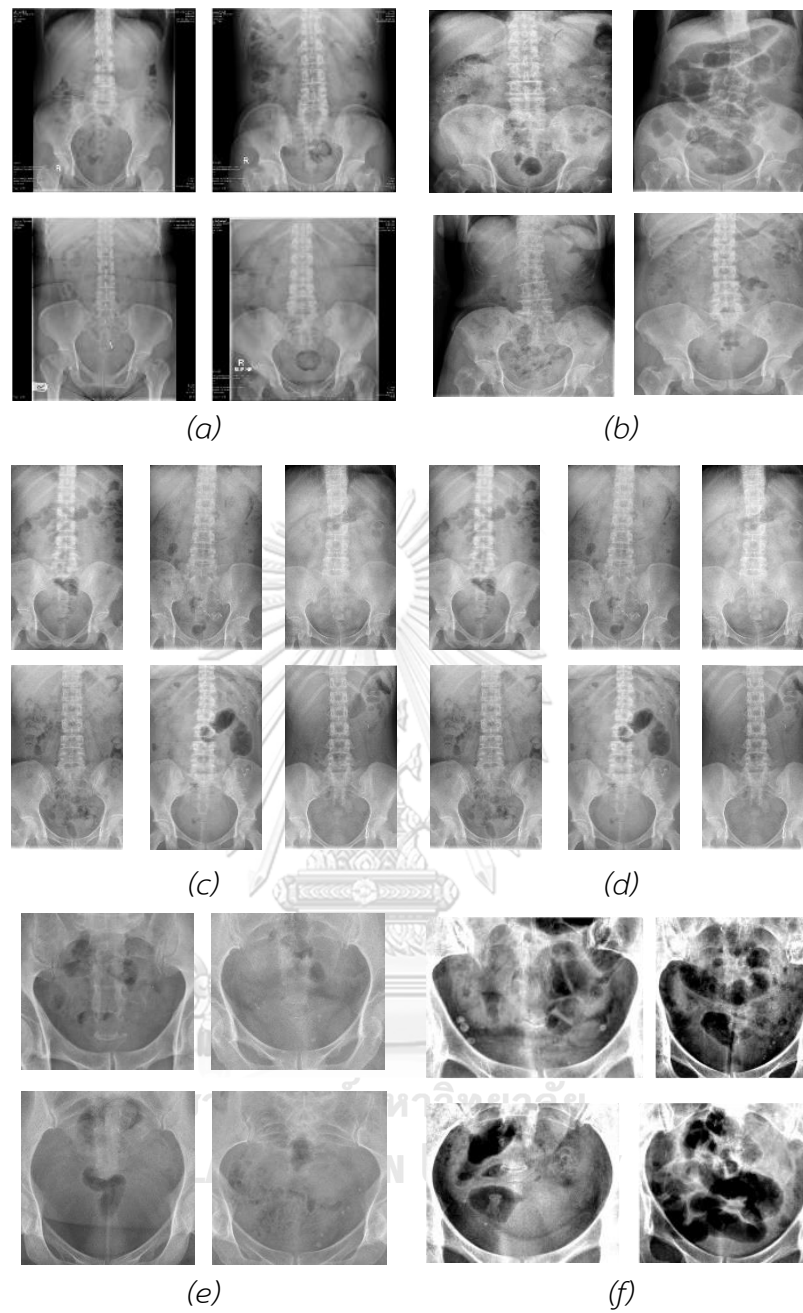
Data preprocessing for abdominal radiograph: (a) original image, (b) original image with CLAHE, (c) auto crop, (d) manual crop, (e) manual crop with manual contrast and (f) auto crop with auto contrast
